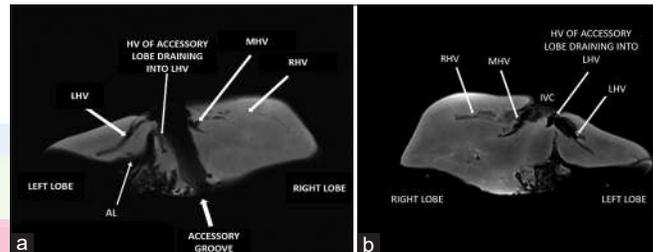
Magnetic resonance imaging (a - Posterior view; b- anterior view) showing the accessory fissure or groove; middle hepatic vein was immediately right to accessory groove; hepatic vein of accessory lobe draining into the left hepatic vein; right hepatic vein
